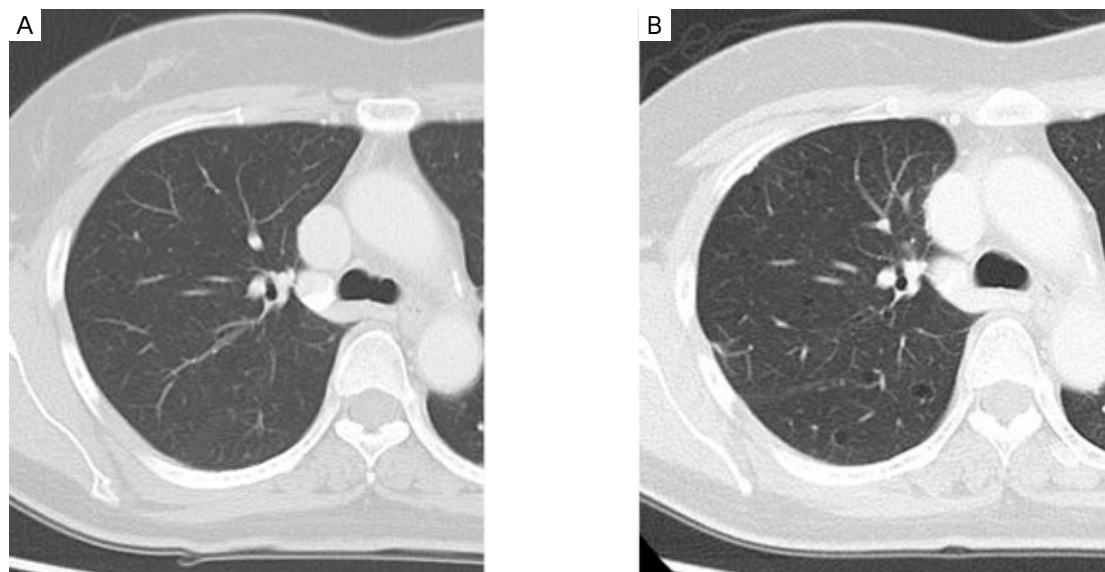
Chest computed tomography (CT) reveals an increase in the number and size of the cystic lesions compared with those 3 years earlier (A, B).
